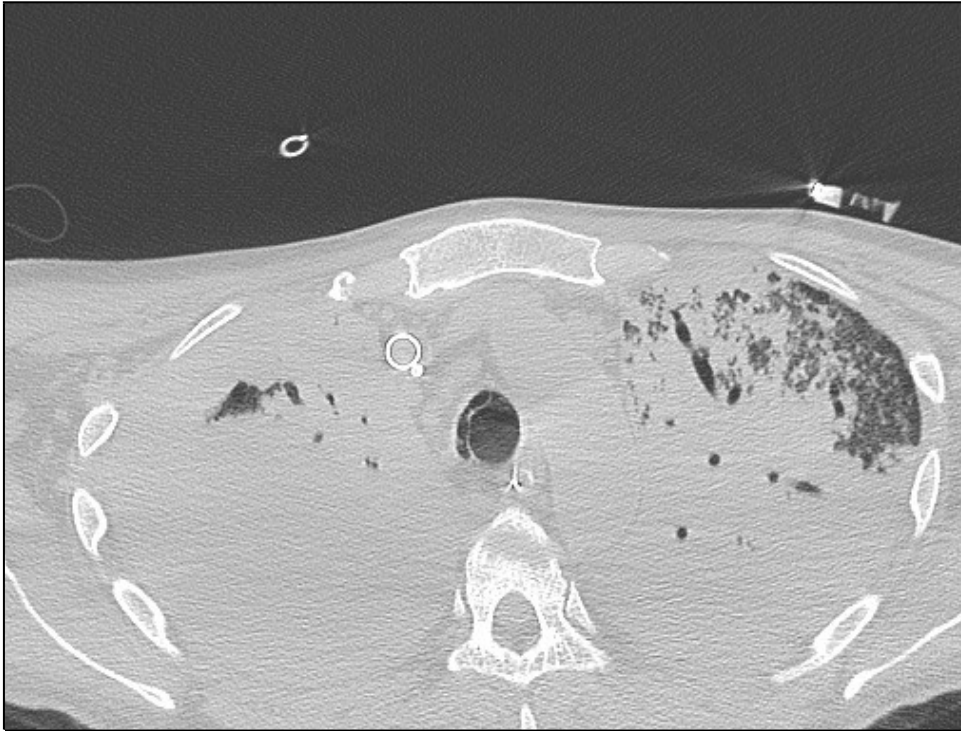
Chest CT showing airless pulmonary tissue with the bronchogram. CT – computed tomography.
